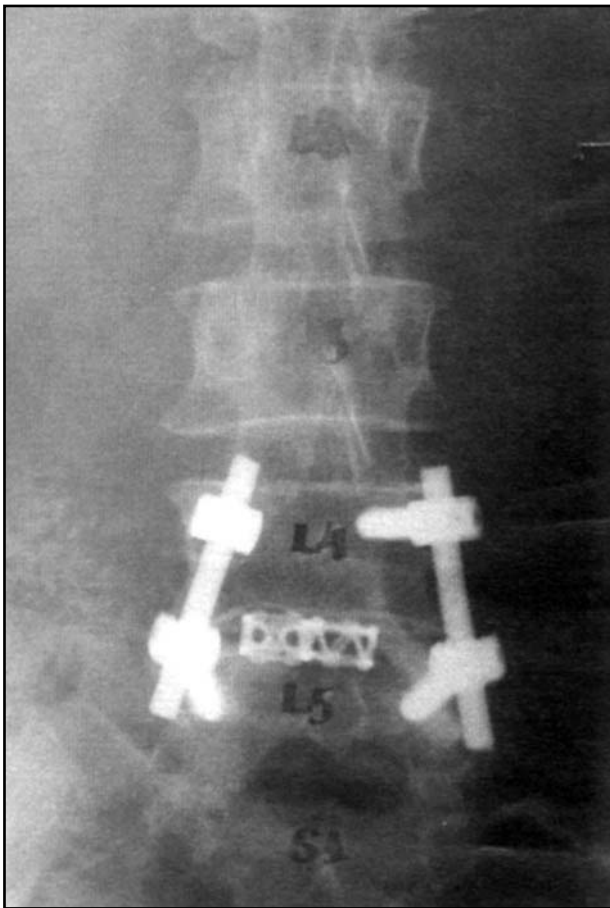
X-ray (AP). TLIF (L4-5).
